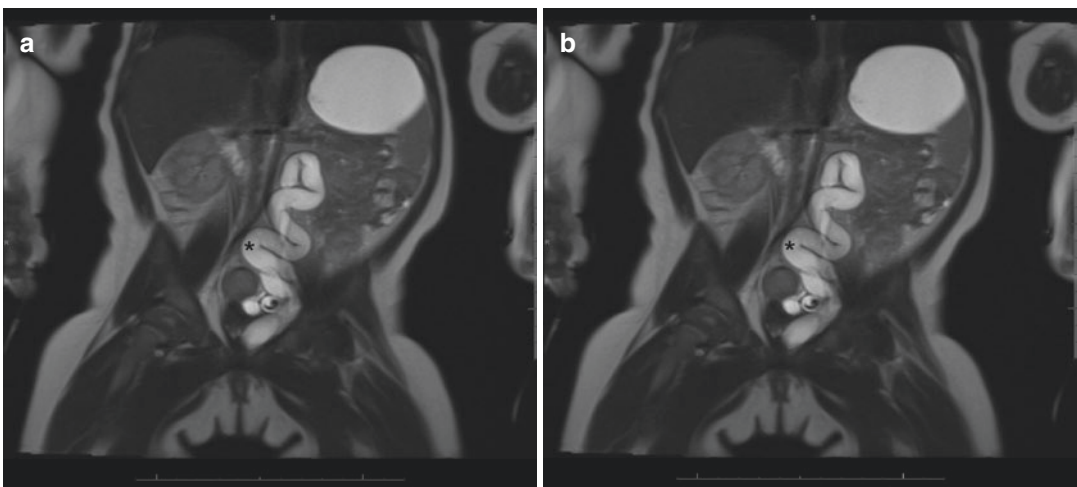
MRI of a five-month-old girl shows duplicating system with hydroureteronephrosis of the upper moiety. (a) Coronal T2 image demonstrating a duplication of the right collecting system (black and white asterisks).
